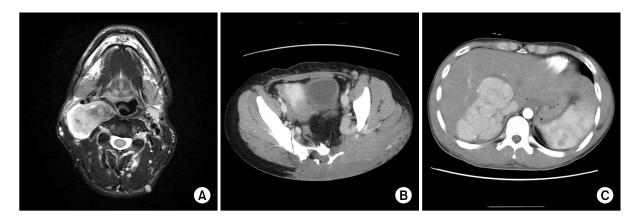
Radiologic appearance of malignant peripheral nerve sheath tumors in different locations. (A) Neck magnetic resonance imaging shows a 7.5 × 5.2 × 3.2 cm sized, heterogeneously high signal mass at right carotid space on T2 weighted image. (B) Pelvic computed tomography (CT) scan shows huge, enhancing mass at left buttock with bony erosion of sacrum, coccyx, and ilium. (C) Abdominal CT scan shows bulky, enhancing mass at right posterior segment of liver.
